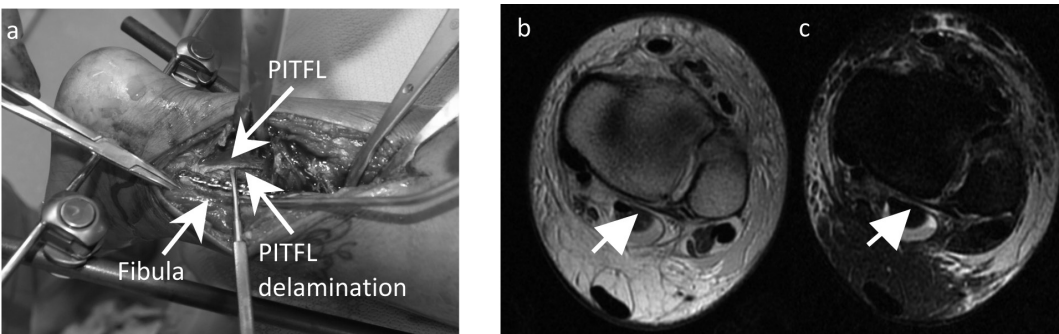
Intraoperative image (a) and axial proton density (b) and short-tau inversion recovery (STIR) (c) magnetic resonance images of PITFL delaminations from the posterior malleolus.
